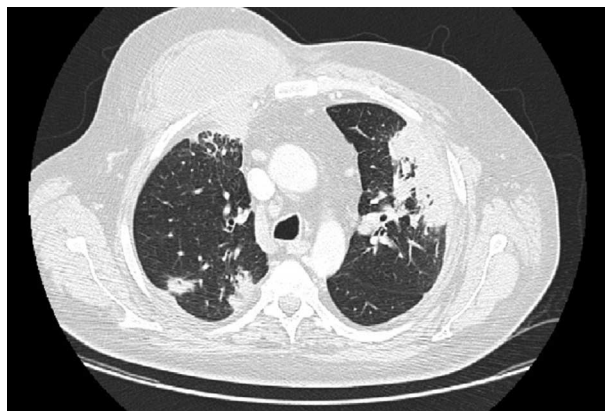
The CT scan shows multifocal, bilateral, nodular, and mass-like consolidation.
